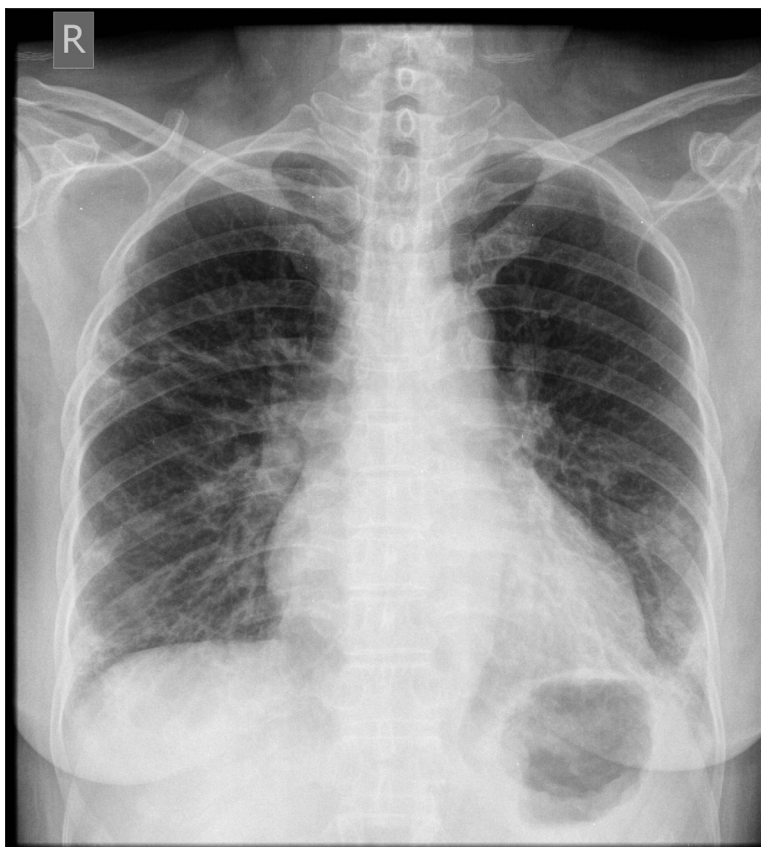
Chest X-ray frontal projection after two months showing multiple bilateral fibrotic bands.
